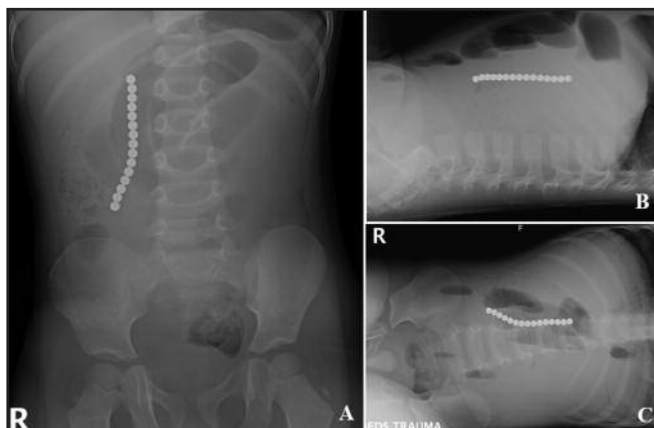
Plain abdominal radiograph showing radiopaque foreign body resembling a string of beads. There is no evidence of pneumoperitoneum.
